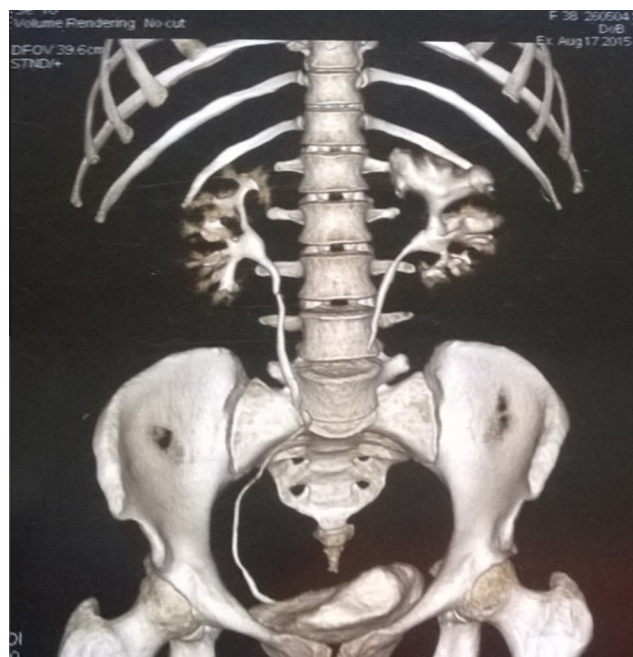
CT showing compressed ureter with hydronephrosis on the left side.
